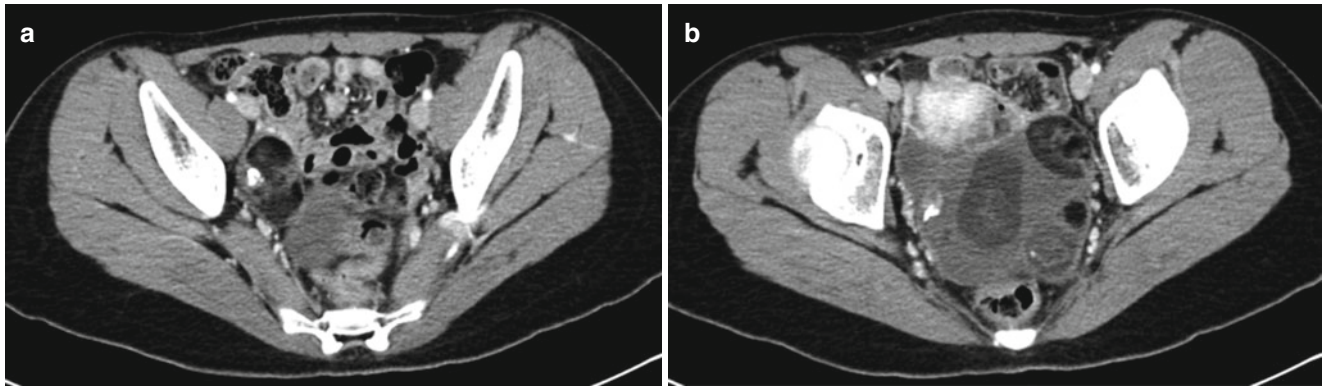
Bilateral ovarian teratomas in a 15-year-old girl. (a) Axial contrast-enhanced CT scan shows a right ovarian mass containing fat and mural nodule with calcification. (b) Axial contrast-enhanced CT
